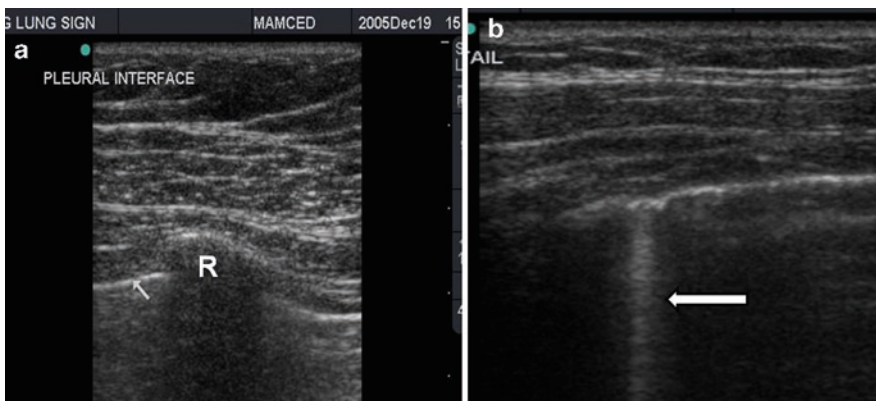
Ultrasound evaluation for pneumothorax performed on anterior chest wall in mid-clavicular line. (a) The hyperechoic pleural line (*arrow*) is identified on the deep surface of the rib (R) which demonstrates posterior shadowing. Visible sliding pleural motion on real-time exam of this area rules out a pneumothorax. (b) Another finding of a negative examination is a comet tail artifact (*arrow*)
